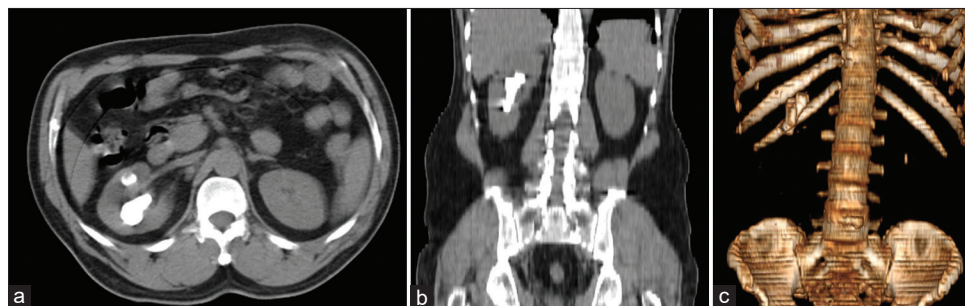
Preoperative computed tomography of the kidneys, ureters, and bladder: (a) Axial, (b) Coronal, and (c) Three-dimensional reconstruction image, showing right renal calculi. There is a small calculus in the left kidney also
